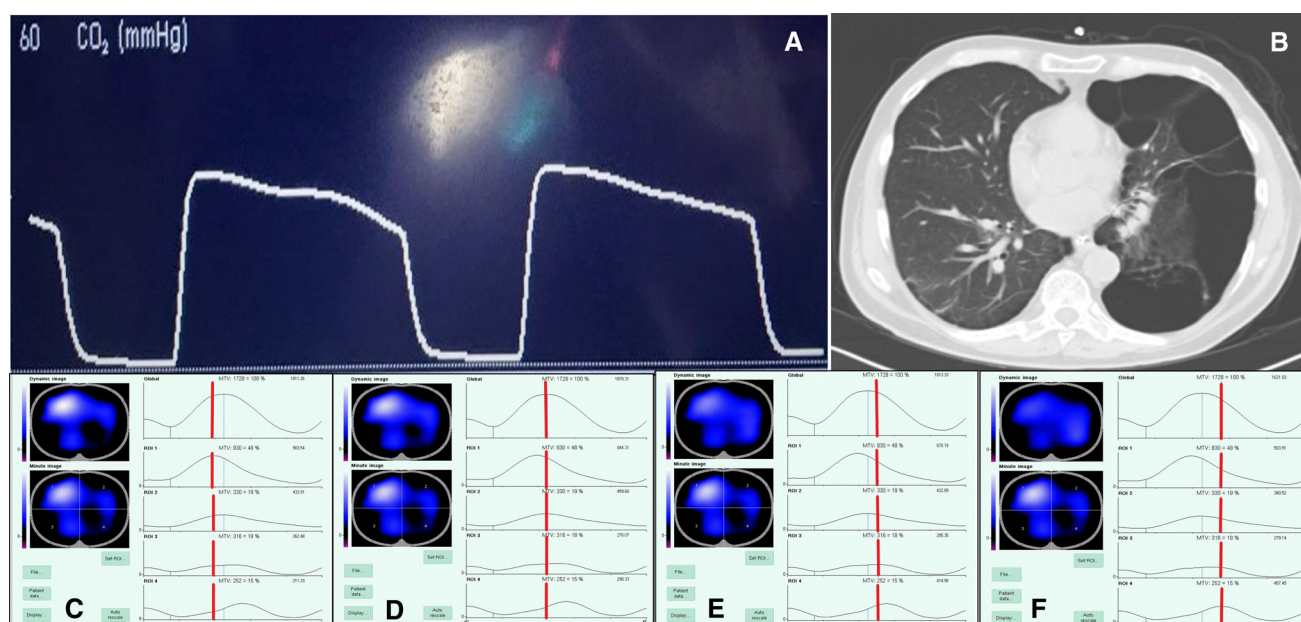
Figure Electrical impedance tomography (EIT) monitoring of a postoperative subject with an unusual descending capnography waveform (*panel A*) and heterogeneous distribution of emphysematous lung changes seen on chest computed tomography (CT) scans (*panel B*). EIT showed that the ventilation was characterized by temporal ventilation heterogeneity, as filling and emptying of different regions of interest (ROIs) in the lung (e.g., ROI-1 to ROI-4, *panels C to F*) were out of phase. Images in *panels C to F*
